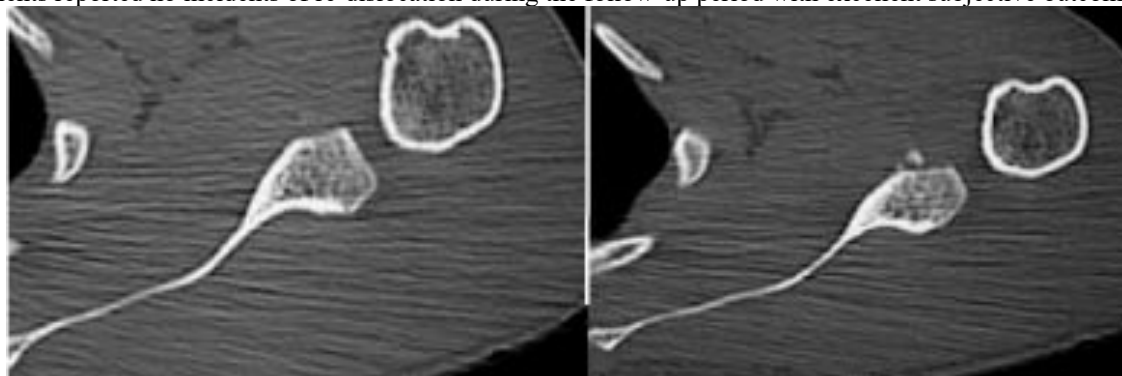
CT scan showing anterior glenoid bone defect
